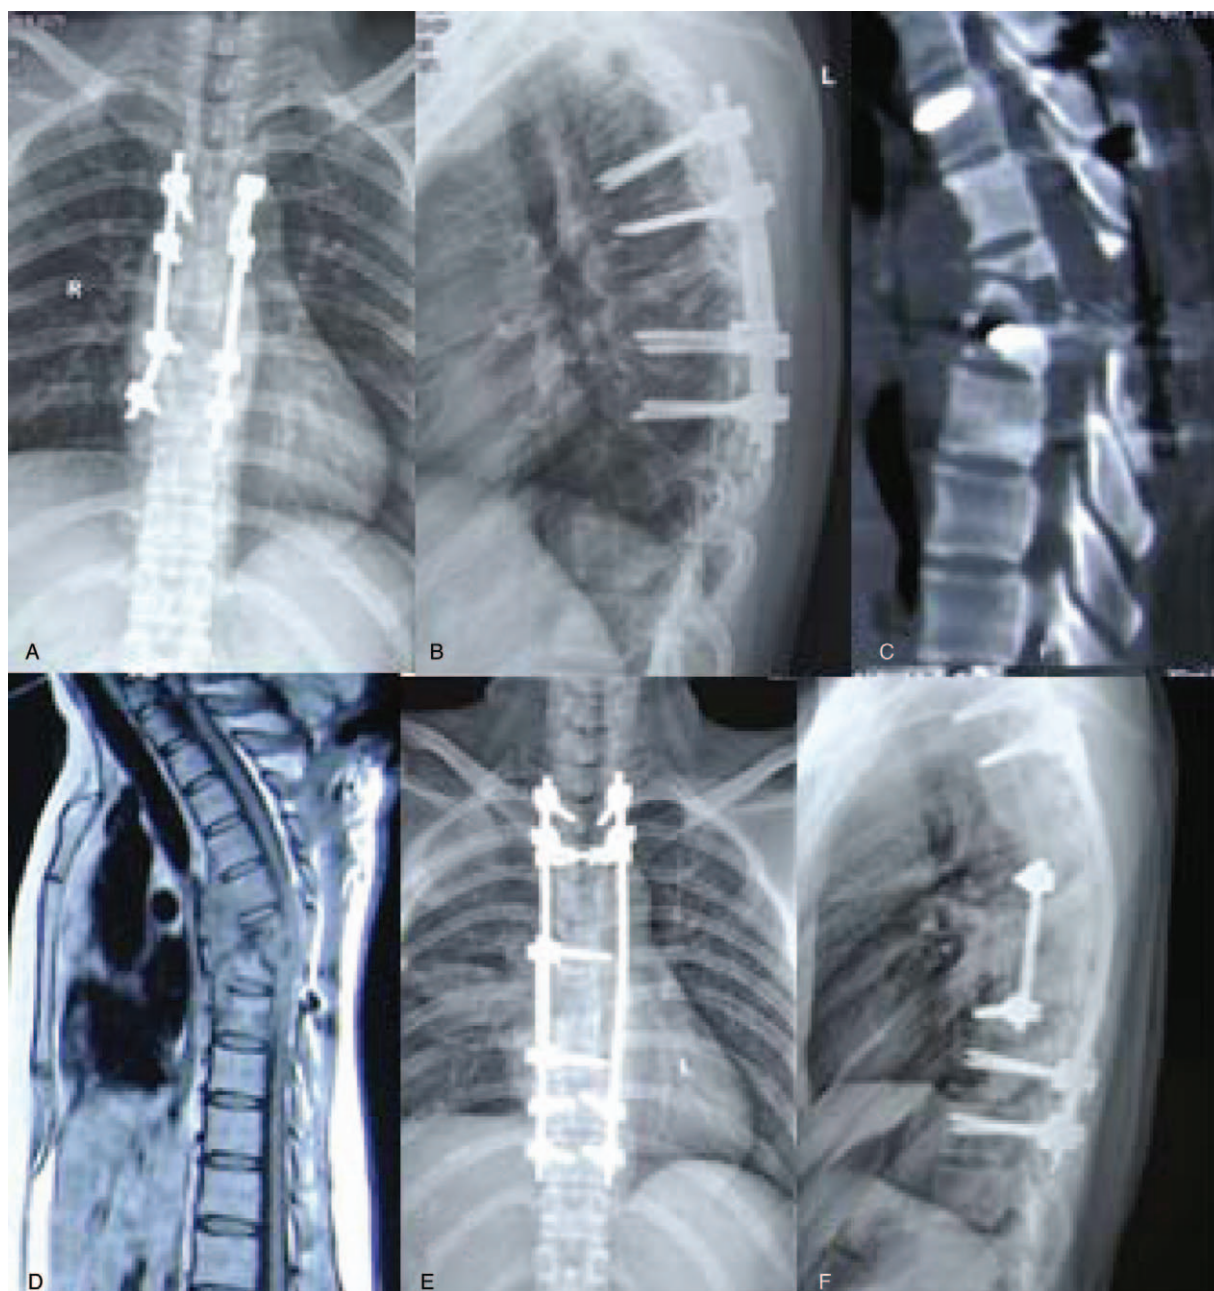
Case 4: A 25-year-old woman with tuberculous spondylitis recurrence after posterior surgery. (A–D) Postoperative radiographs, CT, and MRI showed that vertebral destruction and spinal cord compression after posterior operation. (E, F) Radiographs after surgical revision showed correction of kyphosis and graft fusion. CT=computed tomography, MRI=magnetic resonance imaging.
